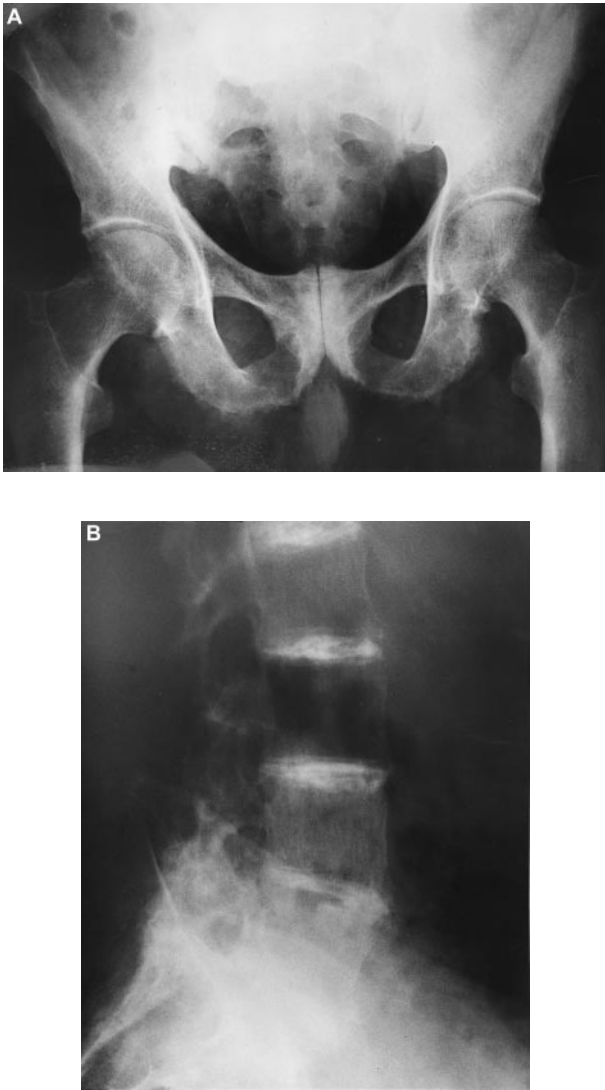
Ochronosis: X-rays of the pelvis (A) and spine (B). Note the sacroiliac involvement, the sclerotic surfaces of the pubic symphysis and the arthropathy of the ischial tuberosity (A) and the characteristic water-like calcifications of the lumbar discs (B).
